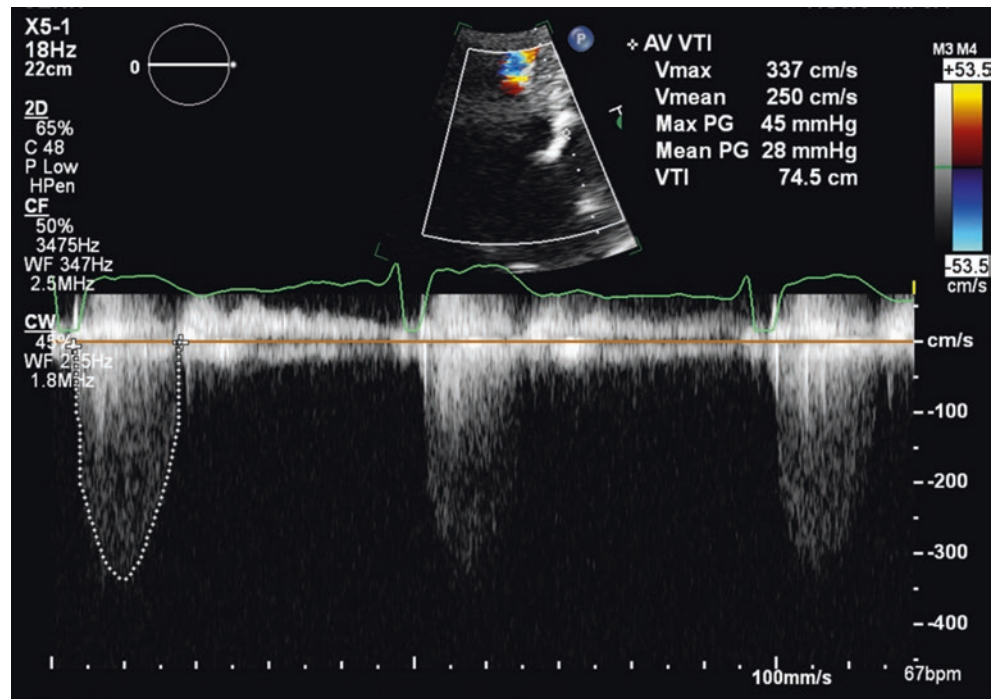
In this case the eccentric aortic stenosis jet causes the inability to align the Doppler beam to obtain the maximum aortic velocity as shown below
